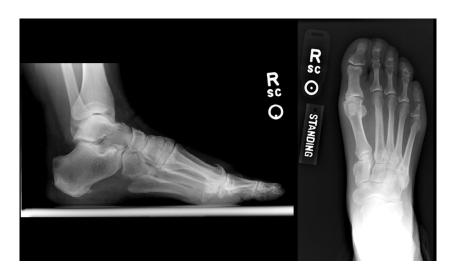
Preoperative lateral and anteroposterior radiographs of a patient with hallux rigidus.
